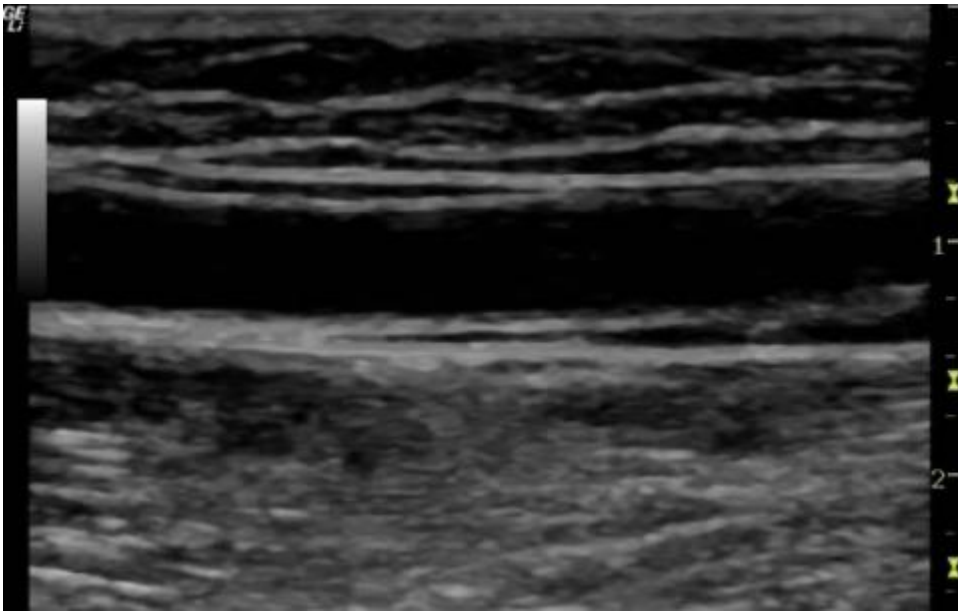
An ultrasound image of a normal healthy vein with smooth, thin walls. *Click on image to enlarge*
